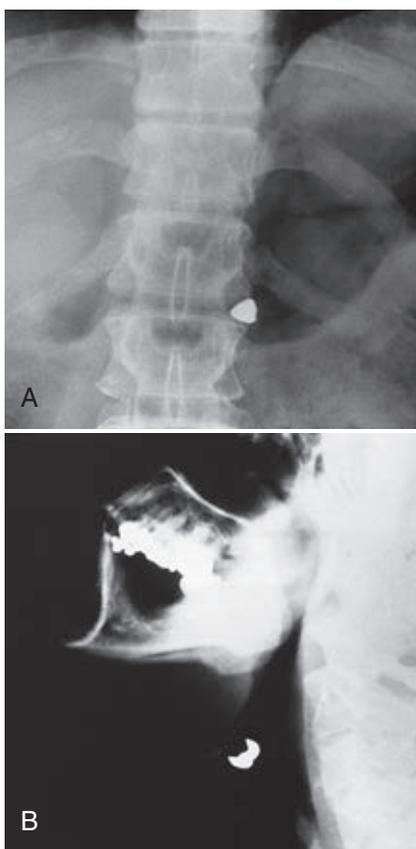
A, Radiograph of swallowed casting in the patient's stomach. B, Radiograph of casting lodged in the patient's throat.
